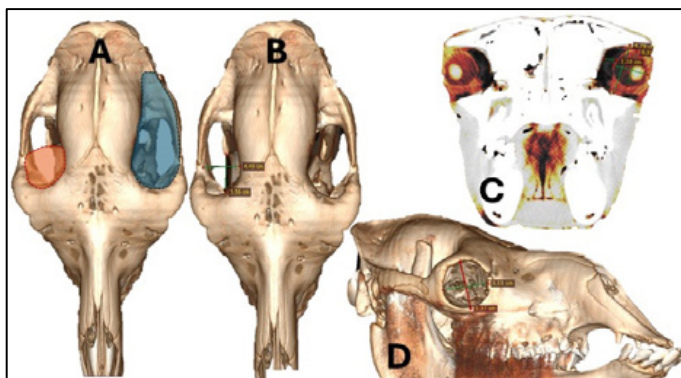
Showing the computed tomographic findings. A) dorsal view of the skull of camel, the orange shaded area is the orbital fossa, blue shaded area is the temporo-orbital fossa. B) dorsal view showing the dimensions of the orbital cavity. C) a slice showing the dimensions of the orbital cavity to that of the eye. D) lateral view showing the orbital cavity dimensions
